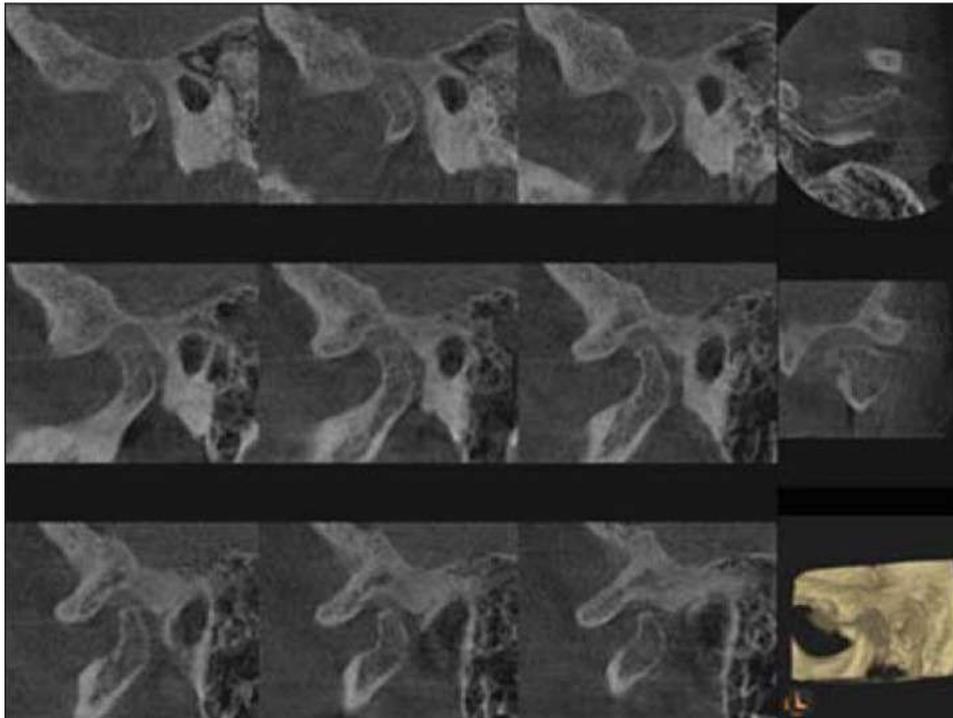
CBCT image showing the right TMJ with 3 dimensional (3D) reconstruction (Krishnamoorthy, Mamatha and Kumar, 2013).
